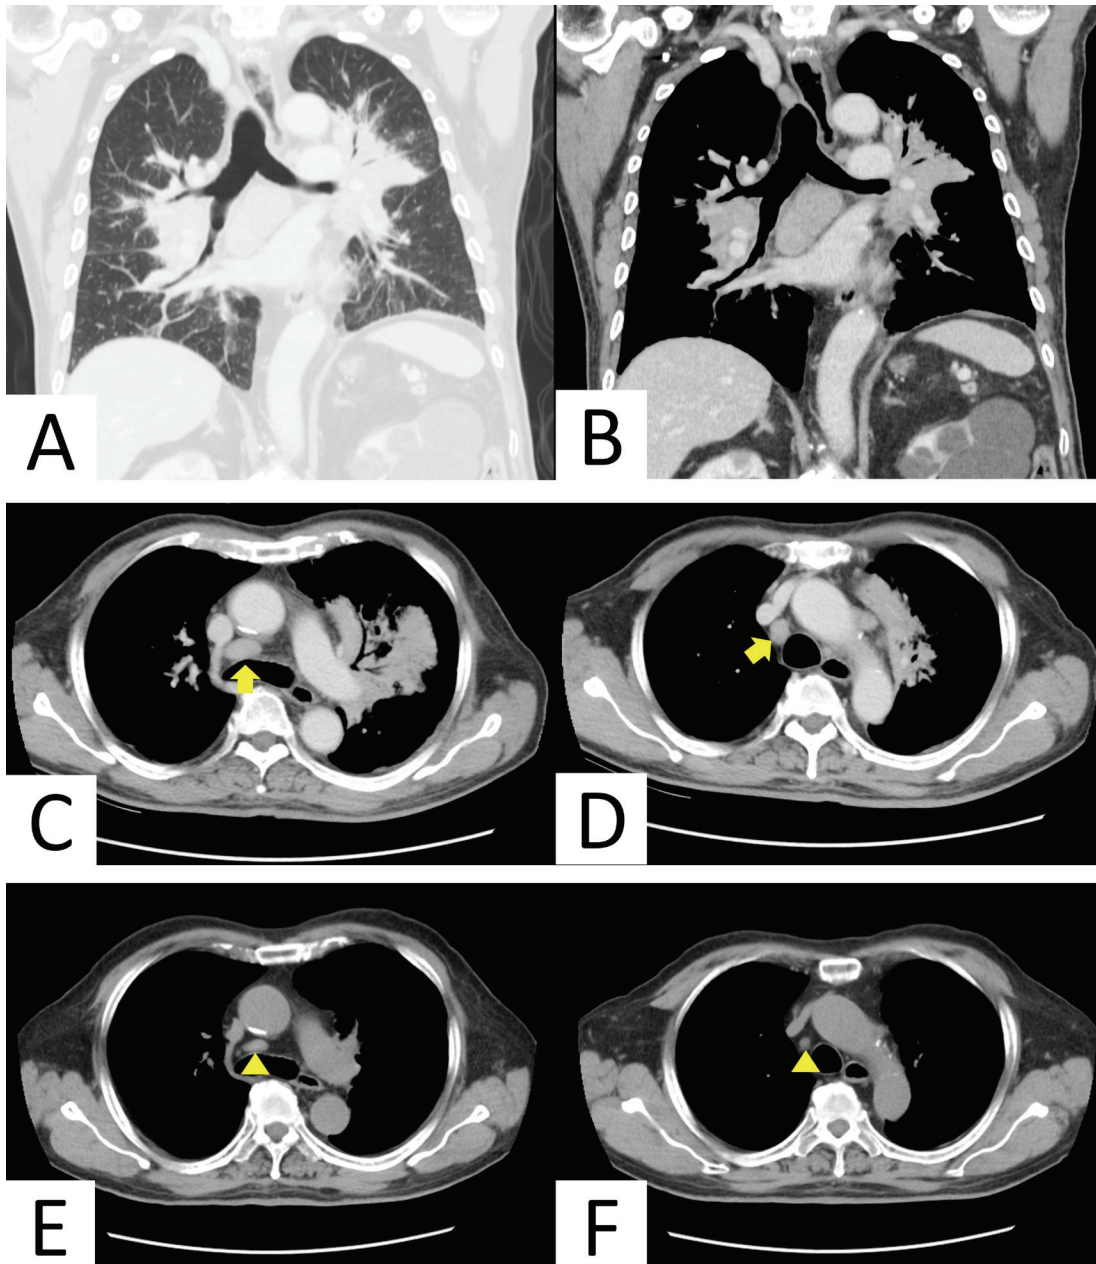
(A)&(B) The initial chest CT demonstrated peribronchovascular consolidations of the bilateral central lungs. (C)&(D) The initial chest CT showed multiple enlarged mediastinal lymph nodes (arrows). (E)&(F) The 6-month follow-up CT revealed that the bilateral lung parenchymal lesions had resolved, and the mediastinal lymph nodes had become much smaller (arrow heads).
